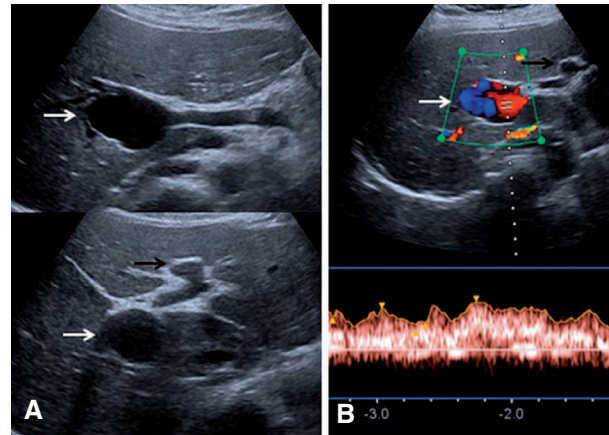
Grayscale US images show portal vein aneurysms of the right (white arrow) and left (black arrow) branches of the portal vein (A). Color and spectral doppler US images show monophasic, turbulent venous flow in the aneurysm (B).
